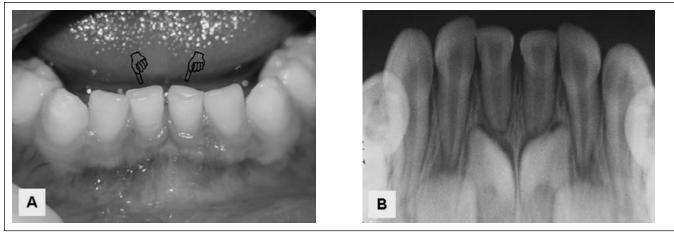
(A) Clinical and (B) radiographic aspects at the 3-year recall appointment. The hypoplastic areas are more visible (pointers); however no invasive intervention was necessary. The radiographic development of the successor permanent teeth is compatible with the chronological age of the child.
